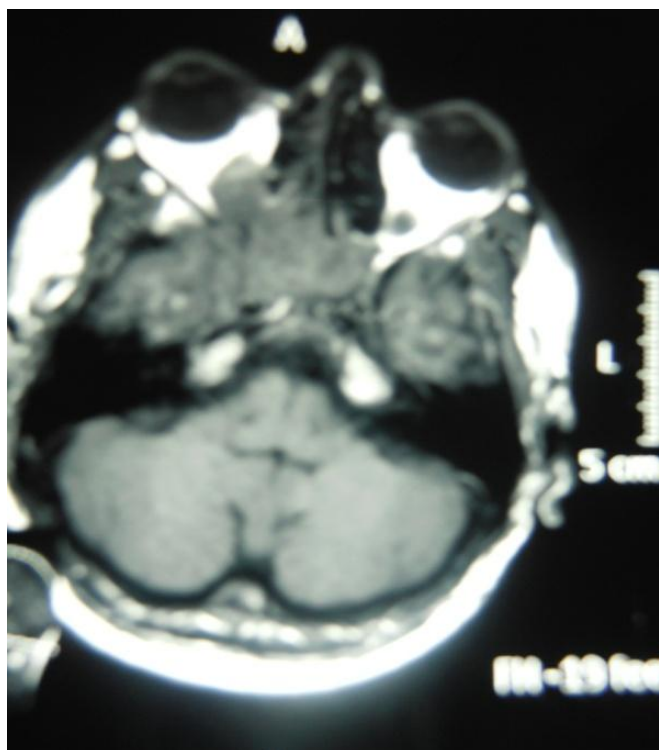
Computed tomography scan of a patient with aspergillosis showing hyperdense lesion in the left temporal lobe.
